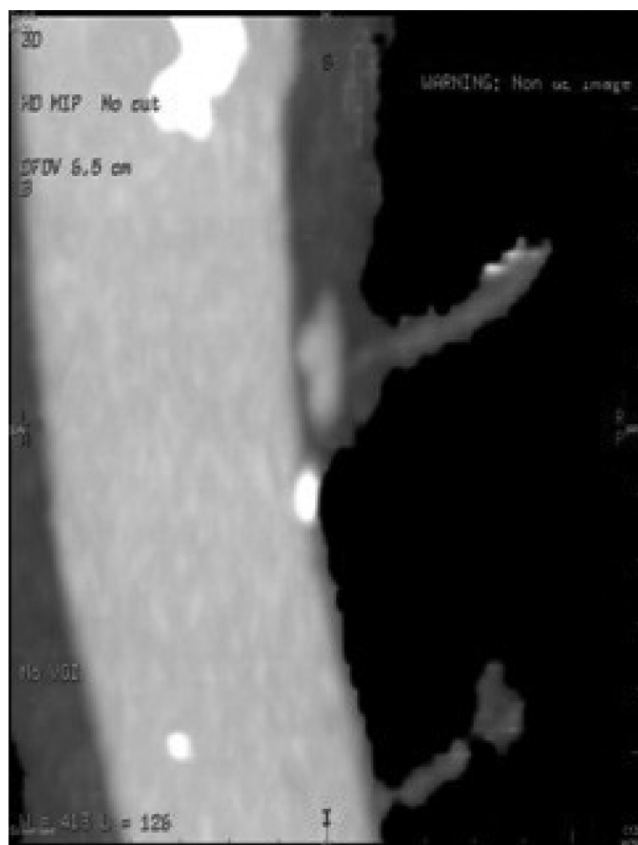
Close up of contrast-enhanced CT scan of the thoracic aorta demonstrating a small collection of contrast in the intramural hematoma representing inflow from the intercostal arteries.
